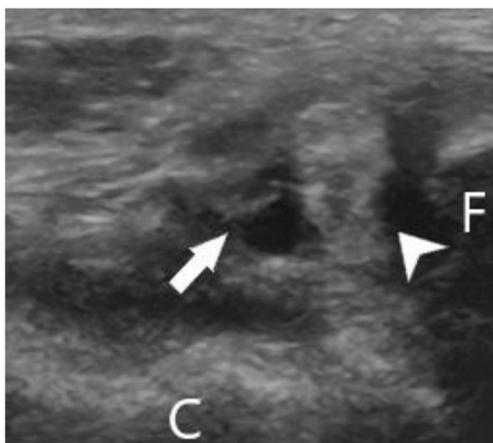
Short-axis ultrasound image in a 66-year-old woman presenting with lateral ankle pain demonstrating the sonographic findings of subfibular impingement, including inferior extension of the distal fibula (*F*) to close to the level of the lateral cortex of the calcaneus (*C*) with interposed fluid and edema (*arrow*). Notice the adjacent peroneal tendons (*arrowhead*), which are susceptible to associated pathological conditions
